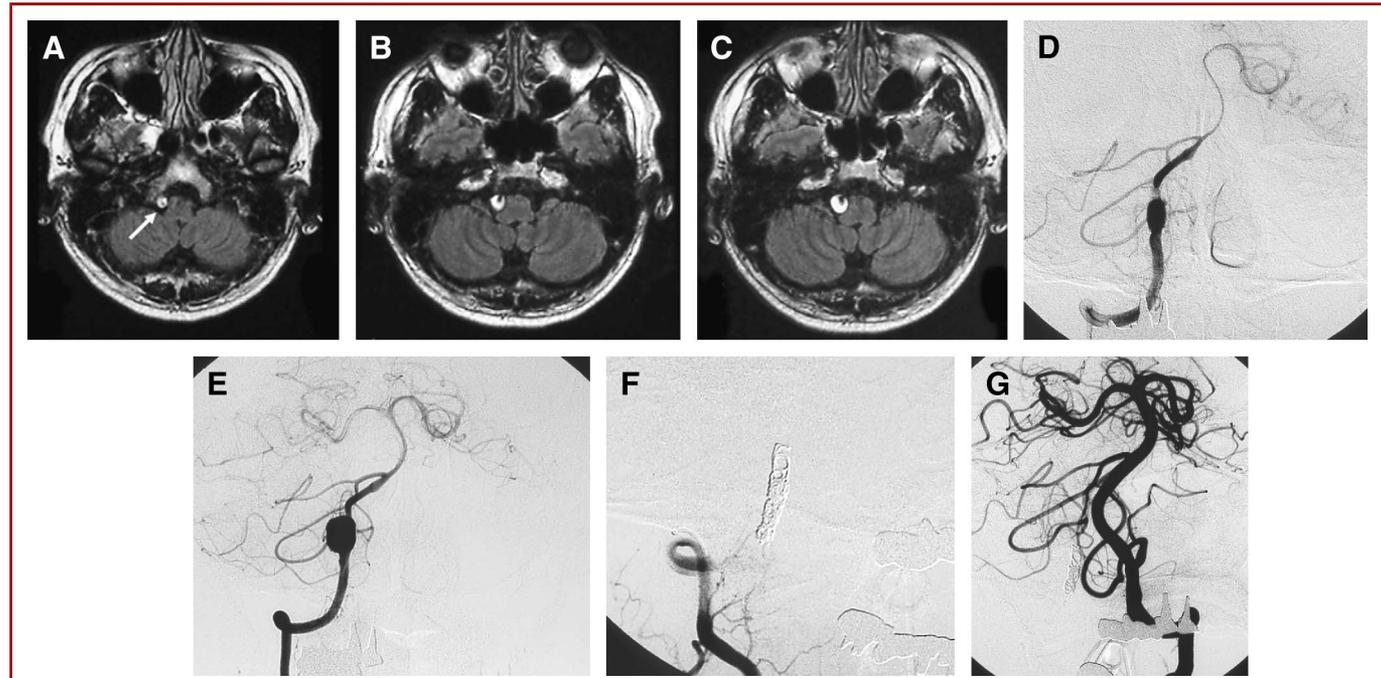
A 44-year-old man who presented with right occipital headache. A-C, fluid-attenuated inversion recovery magnetic resonance imaging. Changes in the right vertebral artery (VA) are visualized as hyperintensity areas. A, admission scan. Hyperintensity signal (arrow) indicative of intramural hematoma in the right VA. B, 1 month post-onset. The lesion shows gradual enlargement. C, 3 months post-onset. The lesion shows further enlargement. D, right vertebral angiogram obtained at admission shows dilation of the right VA proximal to the right posterior inferior cerebellar artery (PICA). E, 3 months post-onset. Right vertebral angiogram shows enlargement of the right VA. F, right vertebral angiogram obtained after embolization of the aneurysmal dilation shows disappearance of the vertebral artery dissecting aneurysm. G, left vertebral angiogram obtained after embolization of the aneurysmal dilation shows preservation of the basilar artery and bilateral PICA, posterior cerebral arteries, and superior cerebellar arteries.
